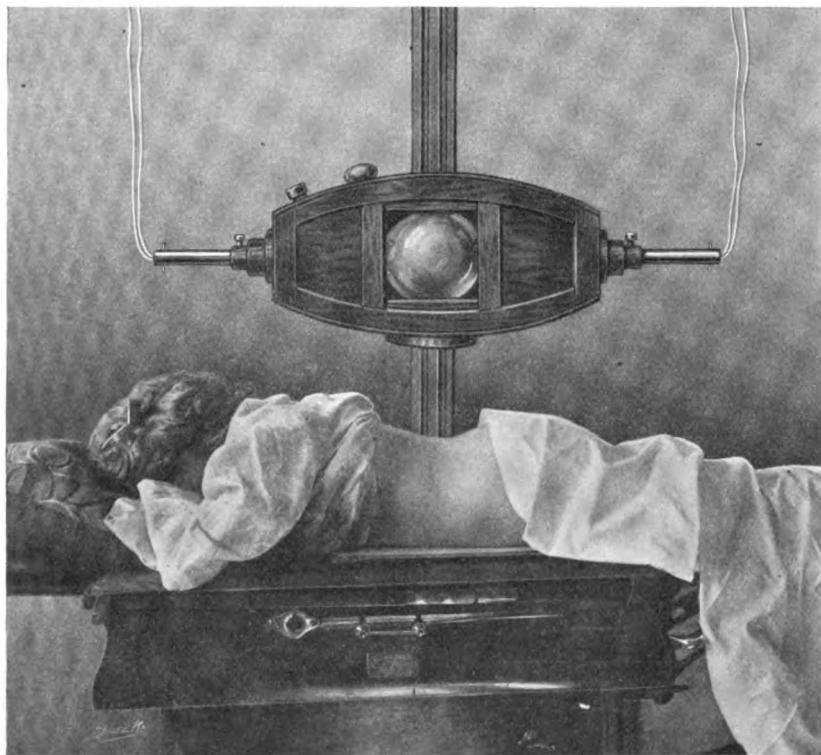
Radiography for biliary calculi. A diaphragm should be used, preferably the author's contact diaphragm with a 2-inch orifice.
